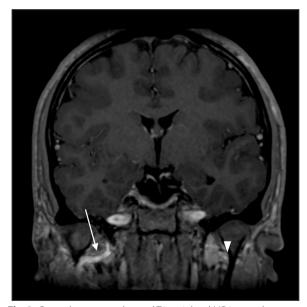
Coronal contrast-enhanced T1-weighted MR image shows an enlargement of the right maxillary artery (arrow) in comparison to the left side (arrowhead)
